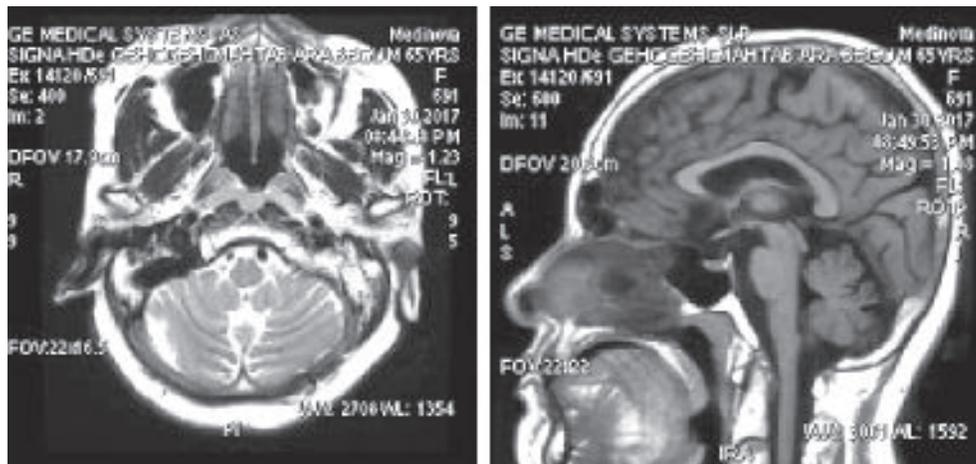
MRI of Brain axial & sagittal view showing bilateral cerebellar atrophy including vermis.
